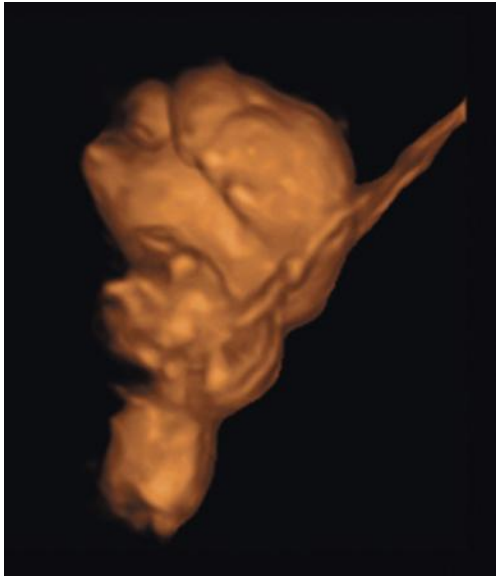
Amniotic band syndrome affecting fetus at 22 weeks 4 days. Ultrasound image with three-dimensional surface rendering demonstrates effects of a tight constricting amniotic band around the fetal forearm with marked distal swelling of the wrist and hand. (Modified from Assaf R, Llanes A, Chmait R: In utero release of constriction amniotic bands via blunt dissection. *Fetal Pediatr Pathol* 31(1):25-29, 2012.)
